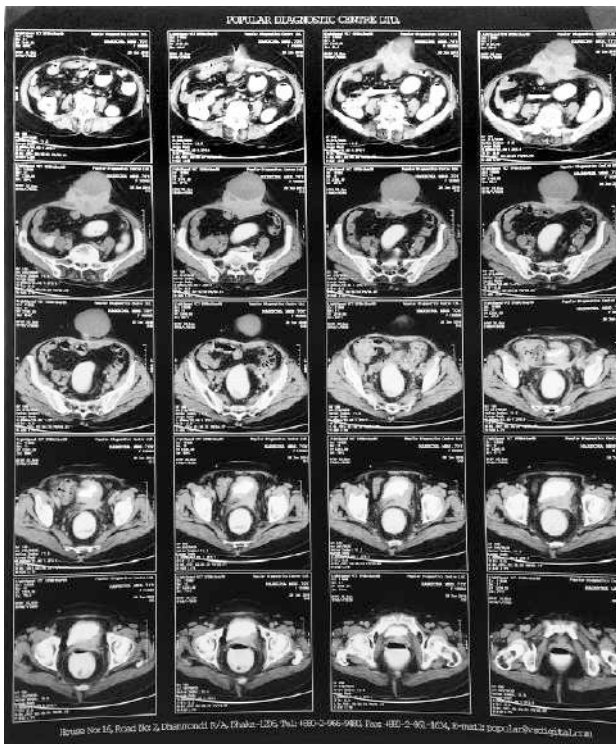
Coronal section image of CT scan of the abdomen showing parietal mass with pelvic vault recurrence.
